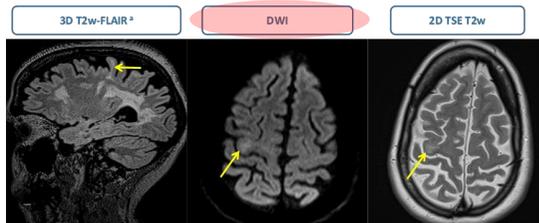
Abbreviated brain MRI protocol for PML screening (observe a small asymptomatic PML lesion in the right pre-Rolandic juxtacortical white matter) (arrows). This abbreviated MRI screening protocol should be performed on a 3-4-monthly basis in high risk patients.
